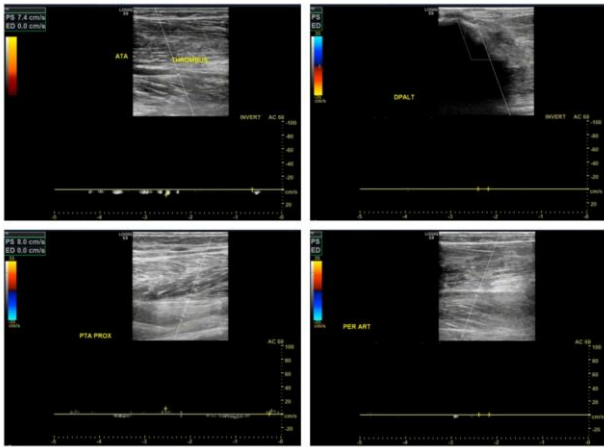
Arterial Doppler images showing occlusion of anterior and posterior tibial, peroneal and dorsalis pedis arteries.
